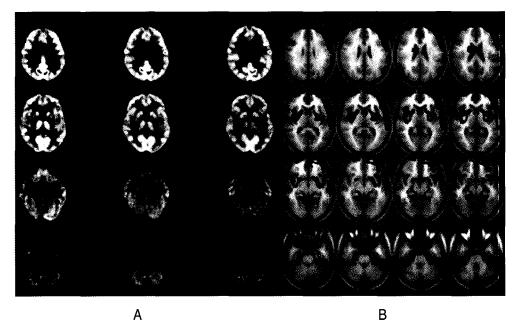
Sixty-seven years old female with multiple system atrophy (parkinson type). Axial image of F-18 FDG PET and SPM results comparing with age matched normal controls show significant hypometabolism of bilateral putamens (especially posterior portion).
